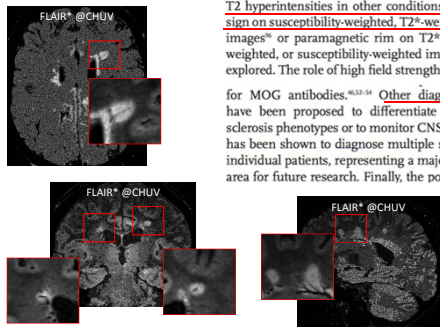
MRI observations that are compatible with MS and other disorders. Axial and sagittal
